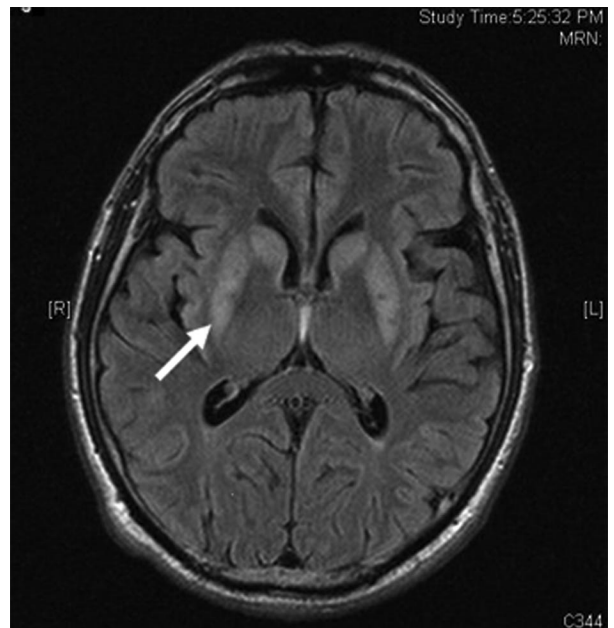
MRI of Brain. T2-weighted MRI of the brain demonstrating basal ganglia demyelination. This is the same patient described in Figure 3. MRI, magnetic resonance imaging.
